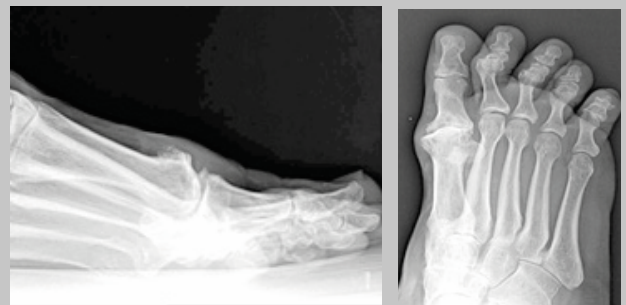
AP & Lateral radiographs
